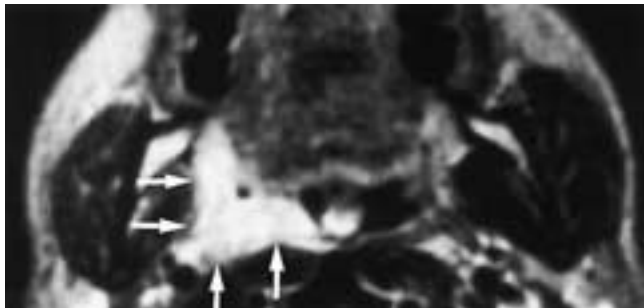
Axial T2-weighted MR image shows thickening and increased signal intensity of the posterior and lateral oropharyngeal walls (*arrows*) consistent with a clinical diagnosis of herpes pharyngitis.
